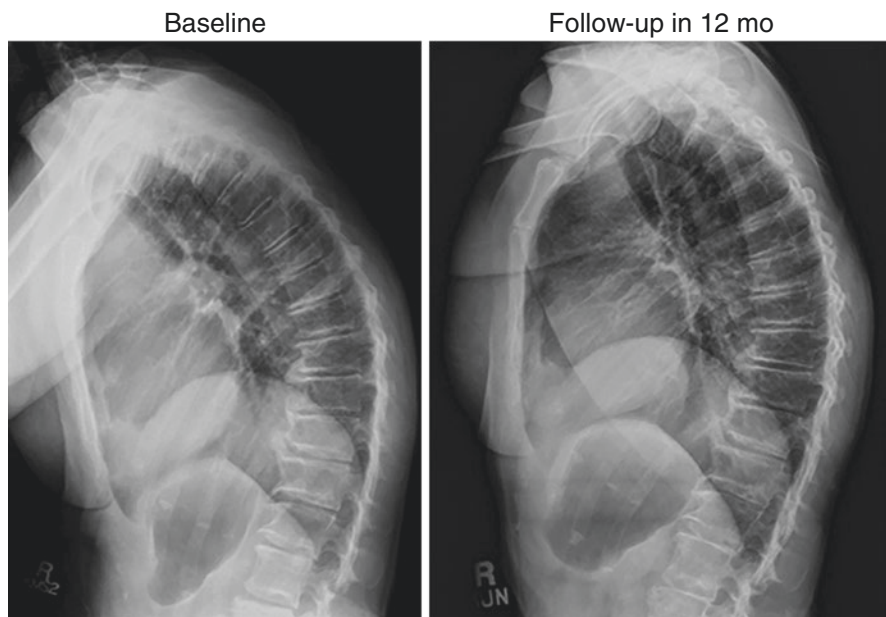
Radiographs depict reduction of thoracic hyperkyphosis from baseline (*left*) to 12-month follow-up (*right*). Radiographic evidence of kyphosis before treatment (*left*) and 12 months after initiating treatment (*right*) with weighted kypho-orthosis and exercise program
